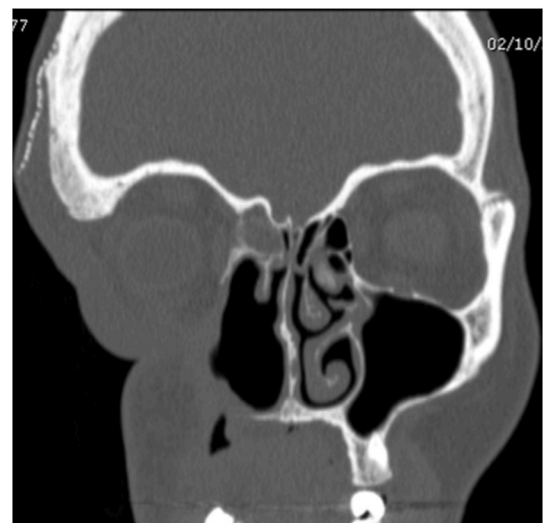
Right minor salivary gland carcinoma: CT finding.
